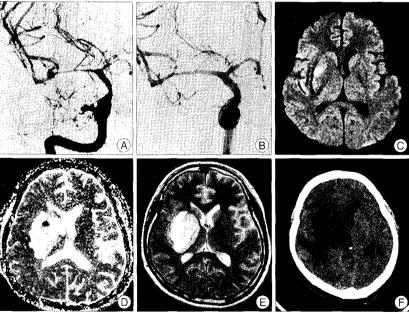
A 40-year-old woman presented with subarachnid hemorrhage from a ruptured aneurysm. A right internal carotid angiography (A) demonstrates severe vasospasm of the middle cerebral artery (MCA) and a saccular aneurysm at the MCA bifurcation (arrow). The vasospasm was resolved after the intra-arterial infusion of nimodipine. Control angiography (B) after infusion of 4mg of intra-arterial nimodipine shows reduction of vasospasm. One day later, a diffusion-weighted MRI (DWI) (C) and apparent diffusion coefficient map (D) reveals a small, acute ischemic lesion in the right basal ganglia. A T2-weighted MRI (E) shows diffuse vasogenic edema of deep brain structure, which is significantly larger than the hyperintense lesion on DWI. The brain CT acquired on the 6th hospital day (F) shows cerebral edema involving the basal ganglia and deep white matter of the right cerebral hemisphere.
